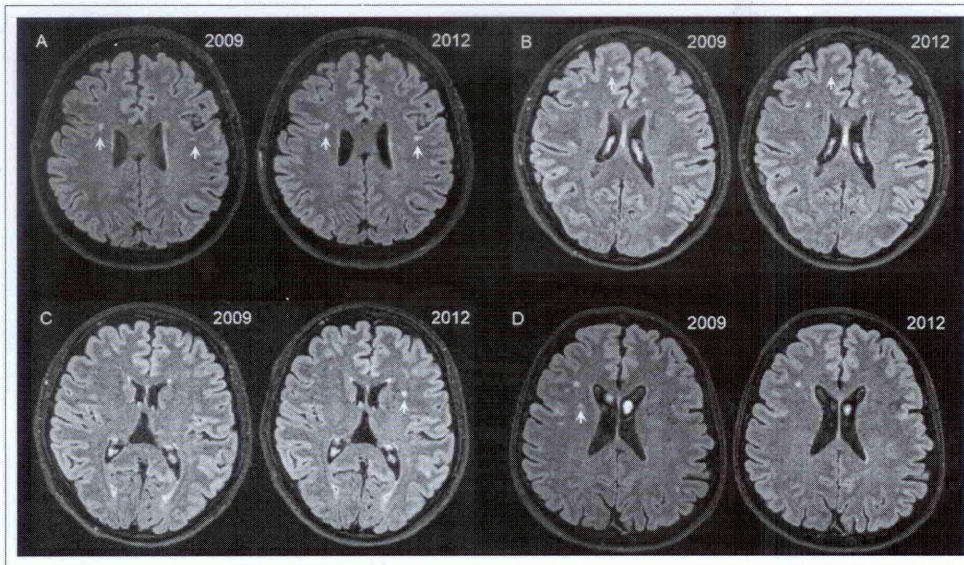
Axial fluid-attenuated inversion recovery brain MRI images of 4 migraine patients. The images show changes between the baseline and the follow-up studies regarding the white matter hyperintensities. These include unchanged right frontal and larger left fronto-parietal bright signal intensities (A), smaller right frontal bright signal intensity (B), appearance of a new frontal hyperintensity (C), and a disappeared frontal hyperintense lesion (D). Images are presented in radiological convention (left = right).
